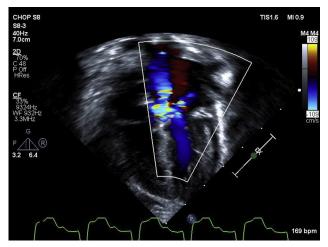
Transthoracic apical view with color obtained approximately 1 week after valvuloplasty shows severe left AV valve regurgitation through multiple jets.
